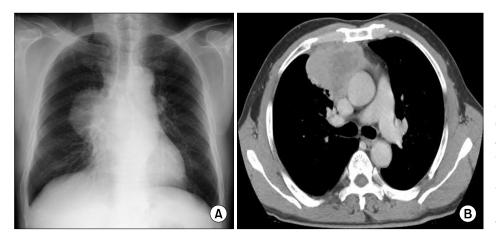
(A) A chest radiograph of case 1 shows a large spherical mass obscuring the right heart border. (B) A chest computed tomography of case 1 reveals a soft tissue mass in the right anterior mediastinum invading the mediastinal fat. No fat plane is seen separating the mass from the ascending aorta.
